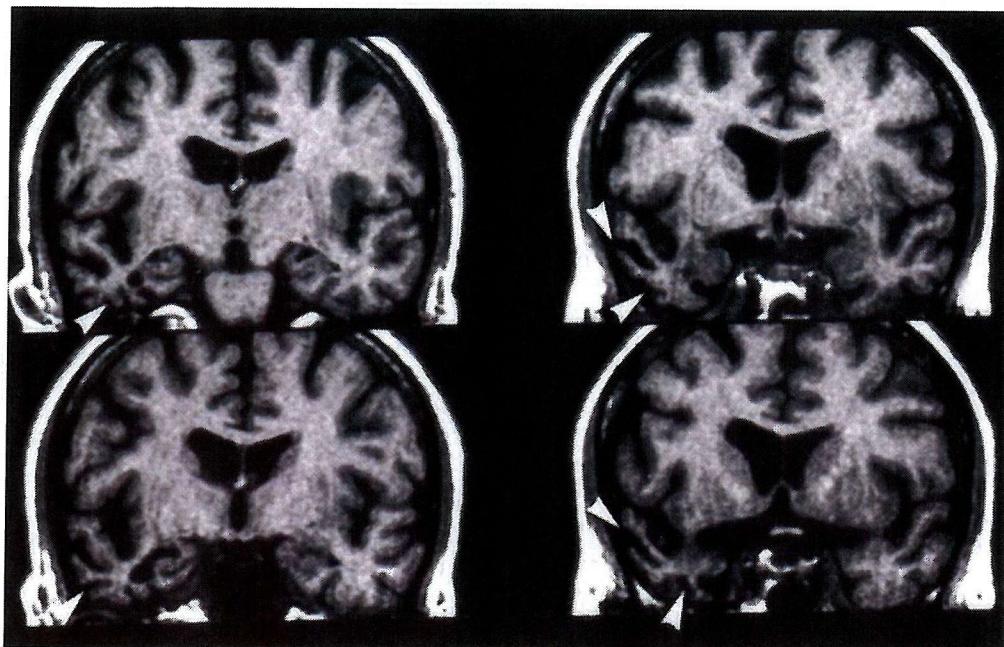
Coronal MRI of patient VH's brain demonstrating selective atrophy of the right temporal lobe (arrowed).
